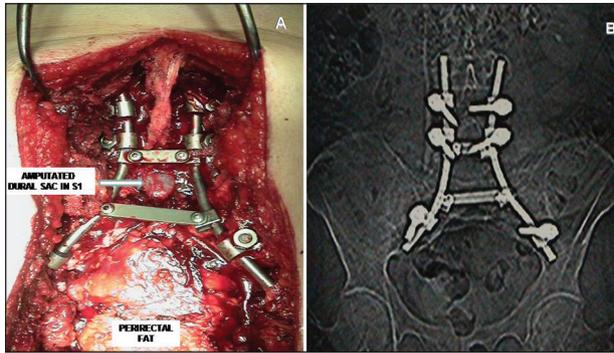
(A) Stabilization including lumbar-sacral fixation and coalition. (B) Postoperative AP X-ray film obtained after total sacrectomy associated to lumbar-sacral stabilization for sacral chordoma treatment.
